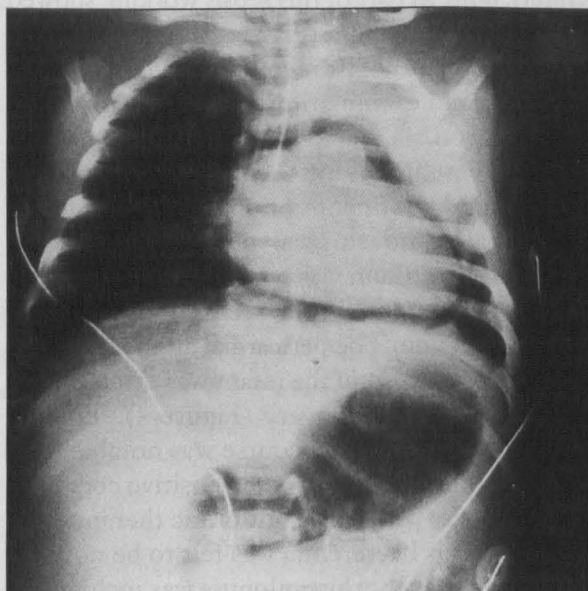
Chest radiograph, day 1, showing the slowly resolving pneumopericardium.
